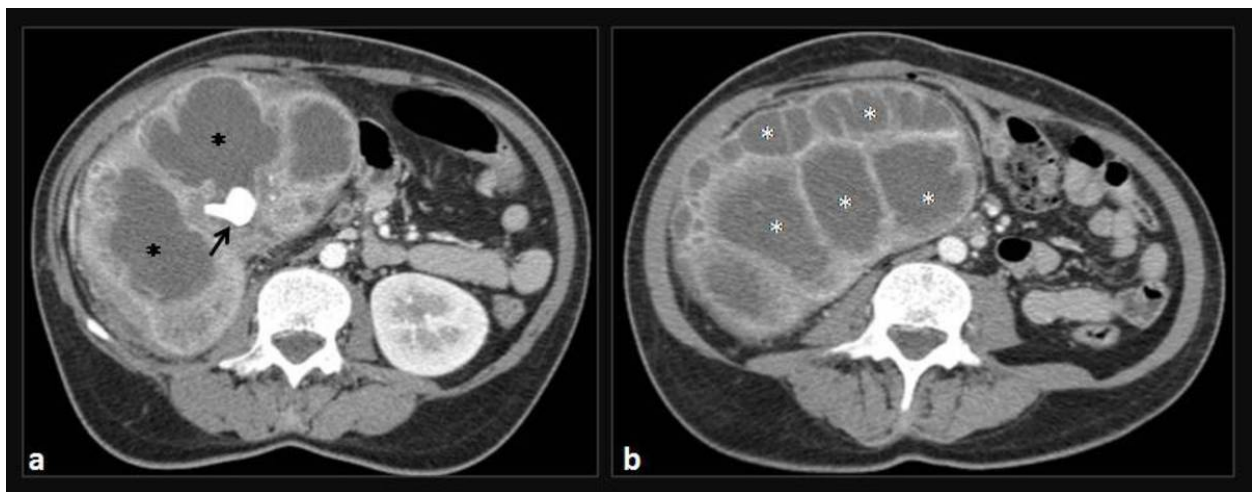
Xanthogranulomatous pyelonephritis (same case as in fig.20). Axial contrast-enhanced CT images demonstrate an enlarged right kidney, with distention of the collecting system (black *) and multiple oval hypodense collections (white *) replacing renal parenchyma. A staghorn-shaped calculus within a relatively contracted renal pelvis is also seen (arrow).
